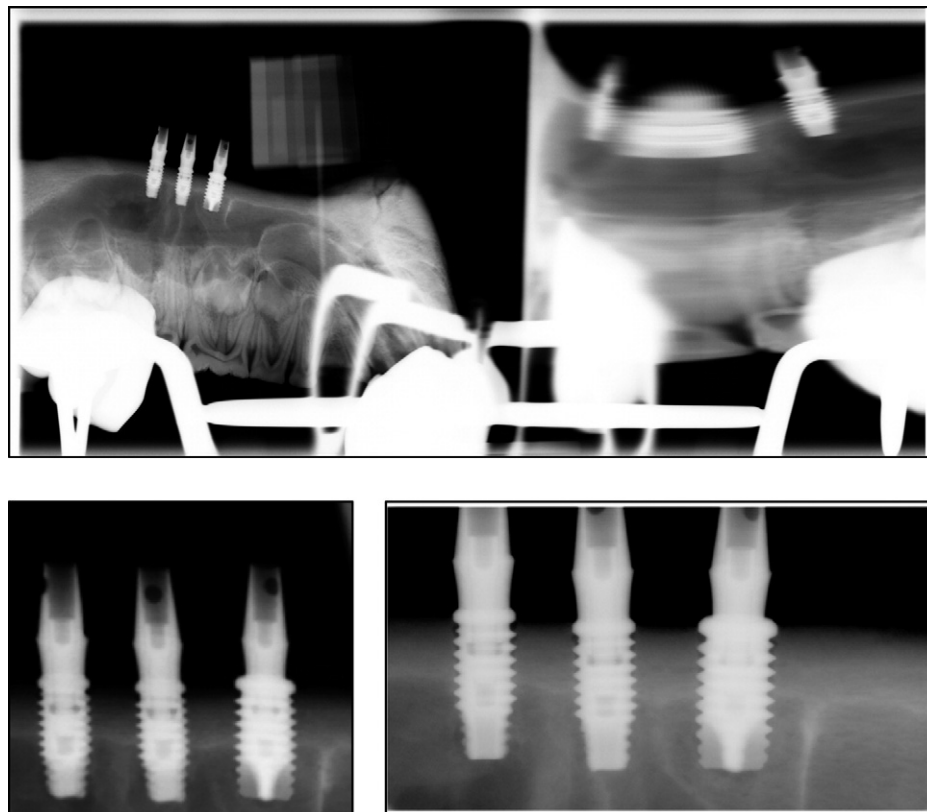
Image preprocessing: original panoramic with 2424×1032 pixels (top), resulting bitmap after preprocessing with 240×220 pixels (bottom left), intraoral x-ray after preprocessing with 458×253 pixels (bottom right).
